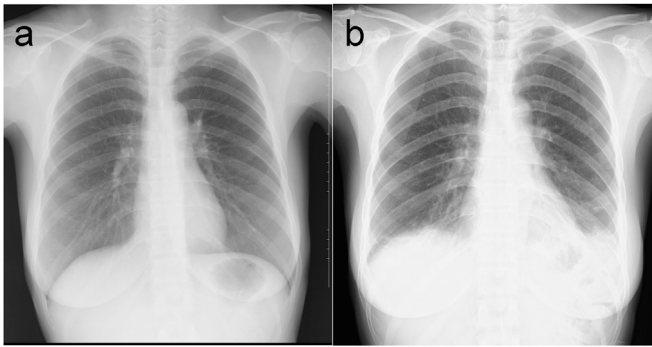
Chest radiographs before and after HPV vaccinations. The pre-vaccination chest radiograph (a) has no abnormalities. The post-vaccination chest radiograph (b) shows patchy infiltrations on both lower lung fields.
